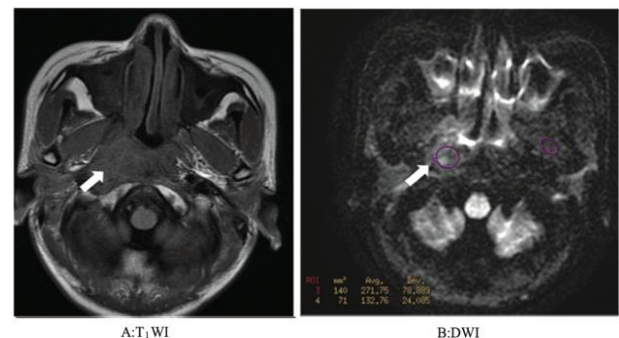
MRI and DWI images of a 22-year-old woman with residual tumor after NPC radiotherapy. A) Mass with the same T1 signal on T1WI (white arrow). B) The lesion is characterized by an uneven and slightly elevated signal on DWI. The ADC value is 1.21×10^{-3} mm²/s. Local tumor residue confirmed by biopsy (white arrow)
